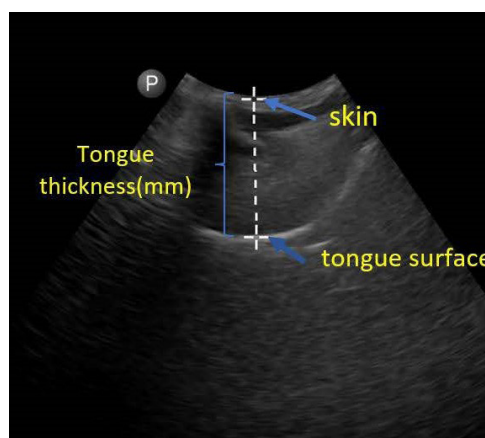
Ultrasound view for the tongue thickness measurement: The maximal vertical dimension is measured from the tongue surface to the submental skin in the median sagittal plane.
